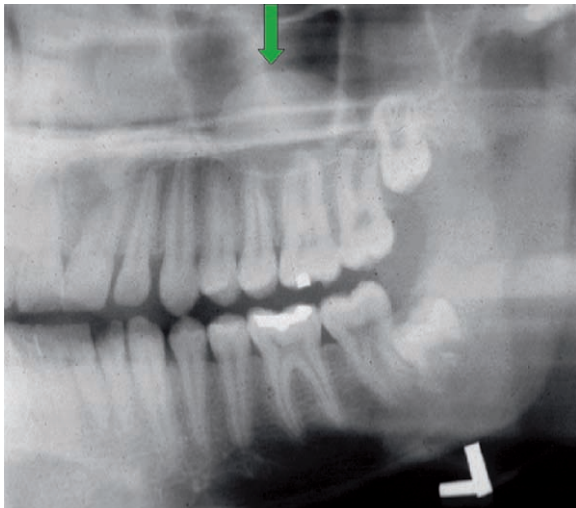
Mucous retention phenomenon: detail from panoramic radiograph shows a smooth-outlined dome-shaped soft tissue density in left maxillary sinus (*arrow*)
